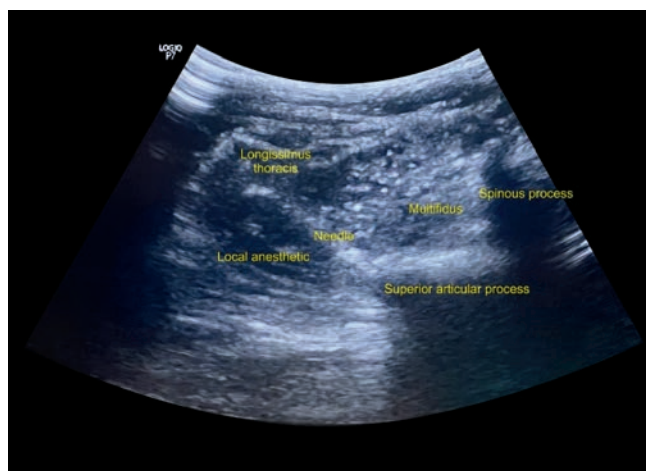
Ultrasound image of thoracolumbar interfascial plane block (TLIP block)
